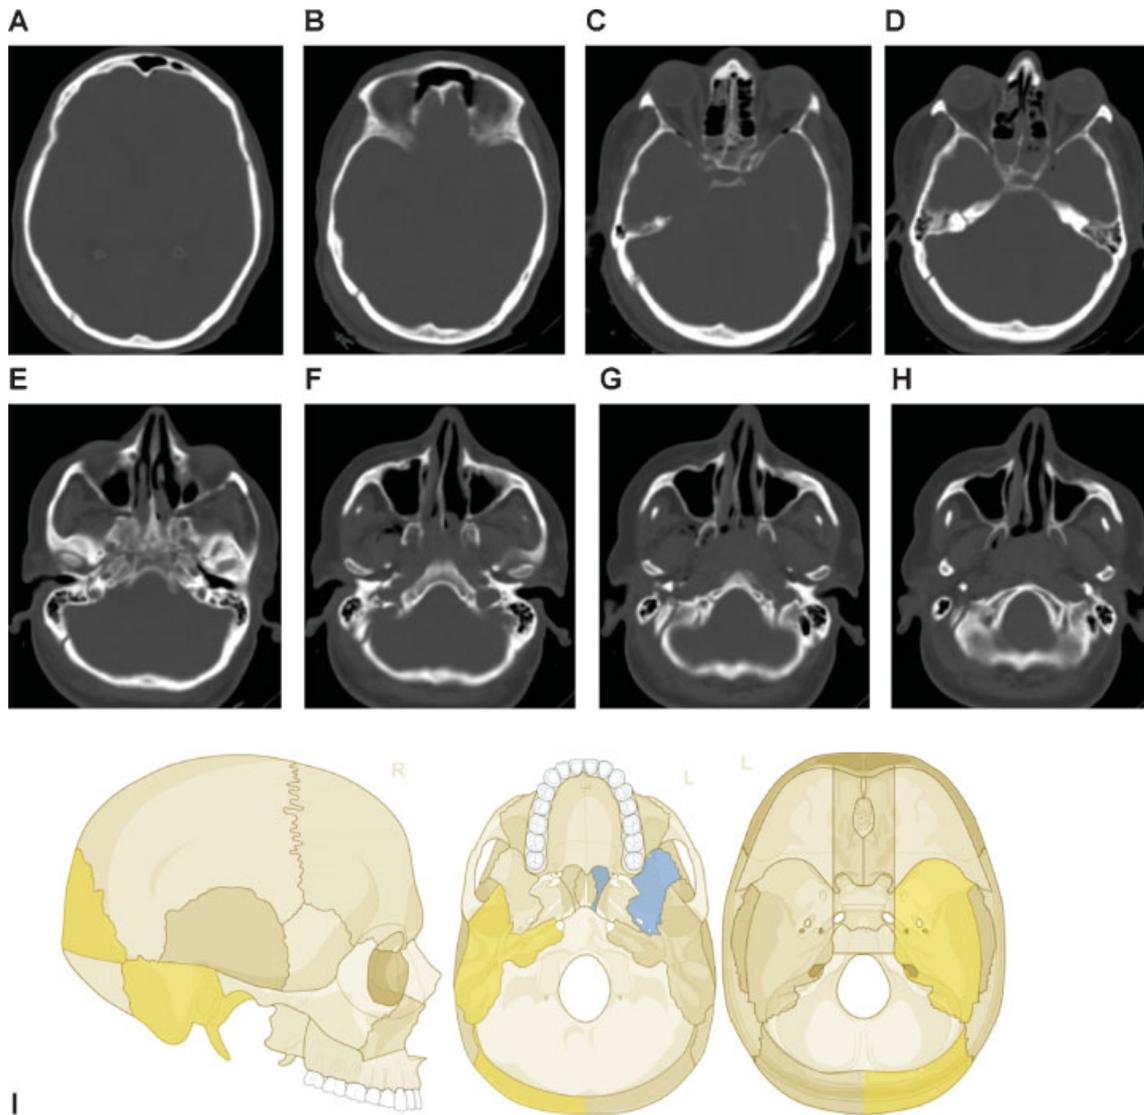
Right occipital and temporal cranial vault fracture extending into the right middle fossa skull base. (A–C) Right occipital cranial vault fracture extending inferiorly into the right temporal bone, (D–H) with extension across the right middle fossa skull base through the skull base portion of the right temporal bone. There does not appear to be any fragmentation. (D) A probable left sphenoid fracture may be noted as well. Imaging: Computed tomographic axial views. (I) Level 3 code: 93 T0.M0.m.S, 94 O0.m. This case example CMTR-93-94-003 is made available electronically for viewing using the AOCOIAC software at www.aocmf.org/classification.
